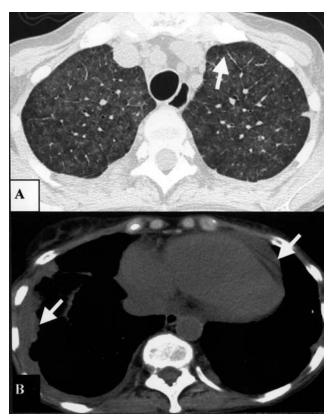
A. High resolution CT of the thorax shows smooth interlobular septal thickening (arrow) and intralobular ground glass opacities. B. CT of the thorax shows right pleural and pericardial effusion (arrows) and incidental left subpleural lymph node.
